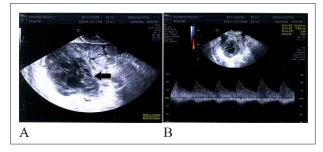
A: Ultrasonography revealed the same size of solid cystic mass (arrow).
